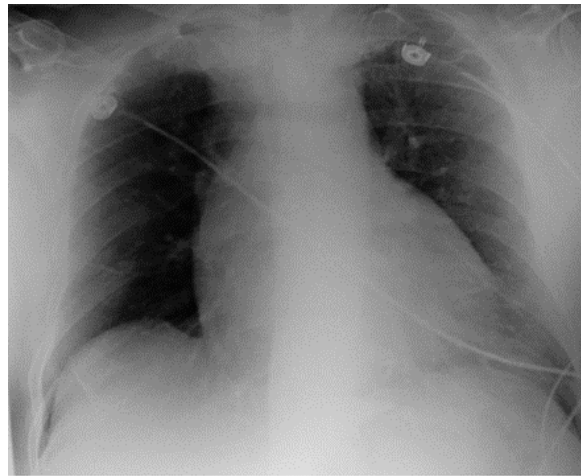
Chest X-ray (PA view) shows increased cardiothoracic ratio
